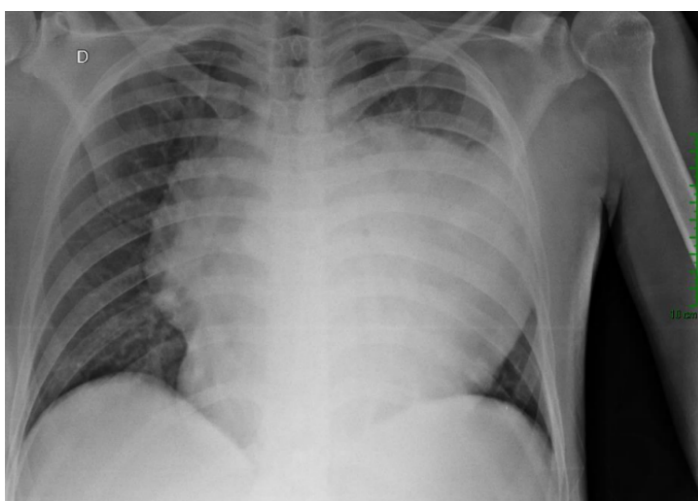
Chest X-ray showing pneumonic process and large mass in the mediastinal region.
